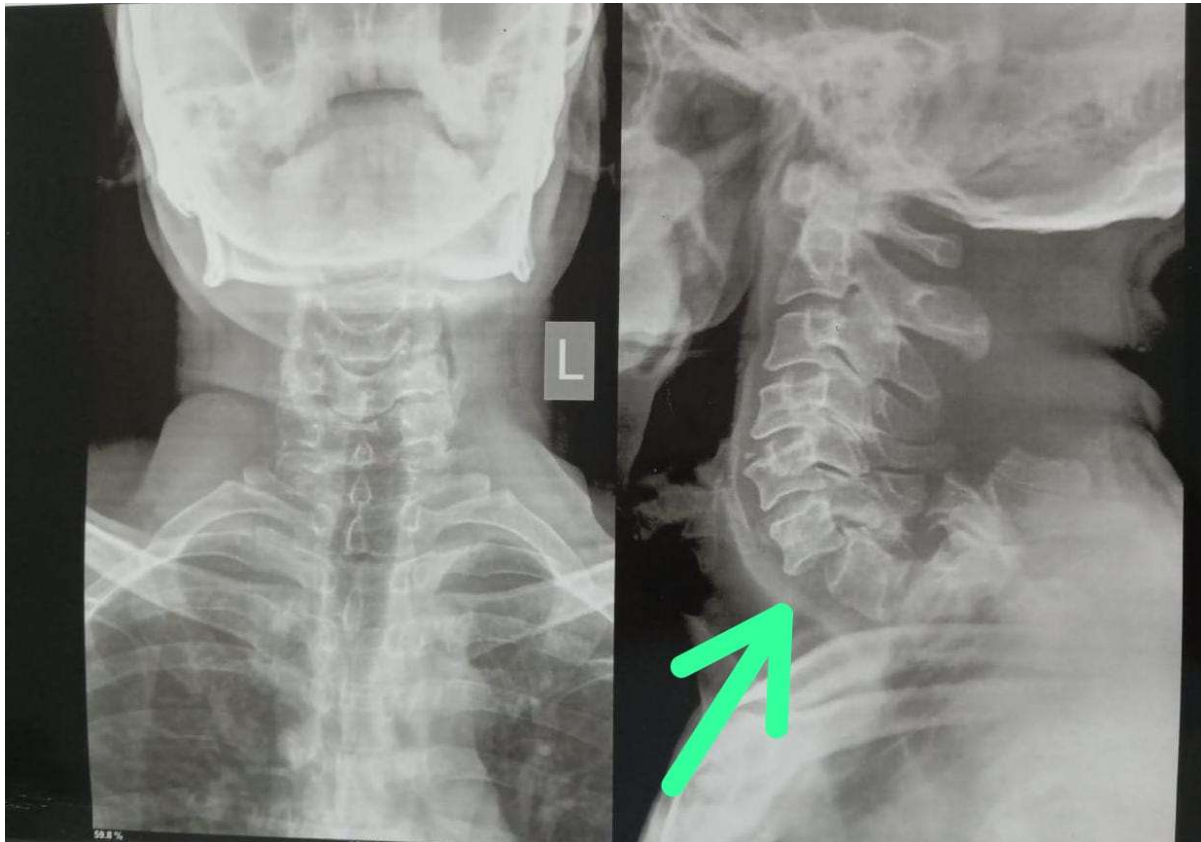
X-ray cervical-spine AP & lateral view (Green Arrow) showing fracture of spinous process of C5, C6 vertebrae
